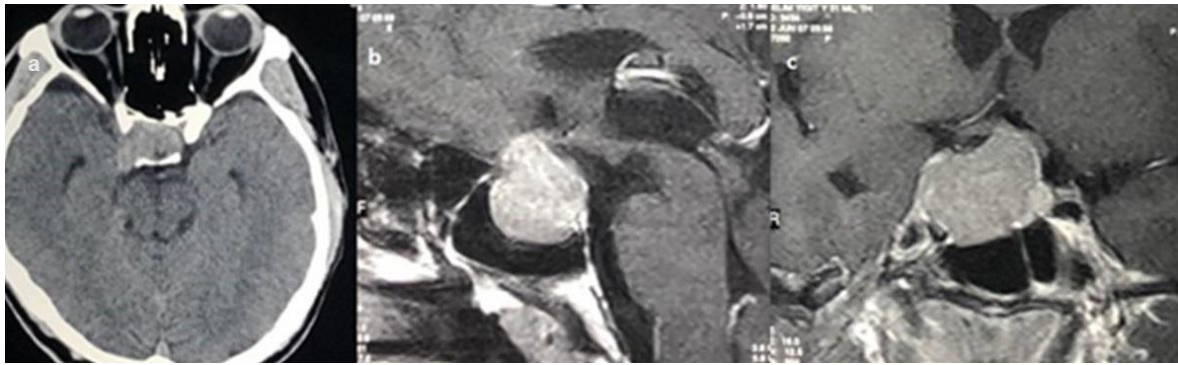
Axial CT (a) and post-contrast T1-weighted sagittal and coronal MR images (b, c) obtained in 2007.
